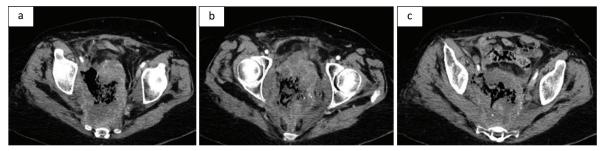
Contrast-enhanced computed tomography (CECT) showing a cervix tumor with the infiltration of the body of the uterus, vagina, rectum, bladder, ureters, pelvic floor muscles and sacrum. No active bleeding was observed but an infiltration of the major vessels, such as the hypogastric right artery, was observed.
